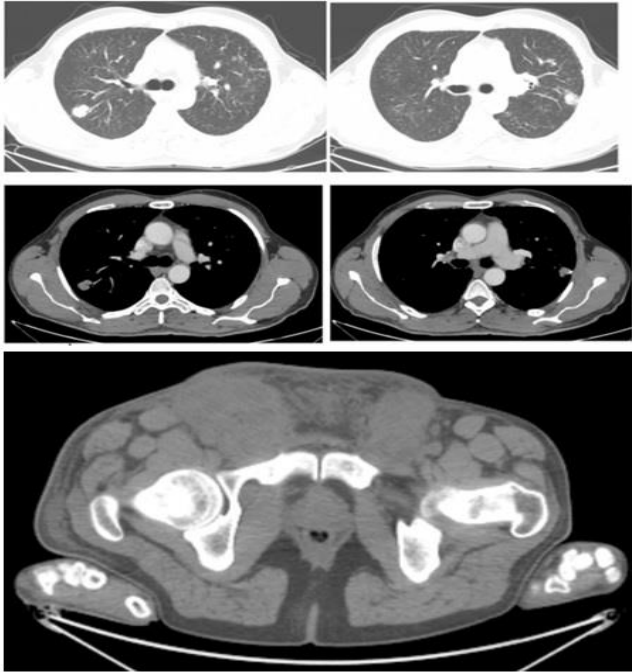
Parenchymal Lung Nodules and Inguinal Lymph Node on CT
